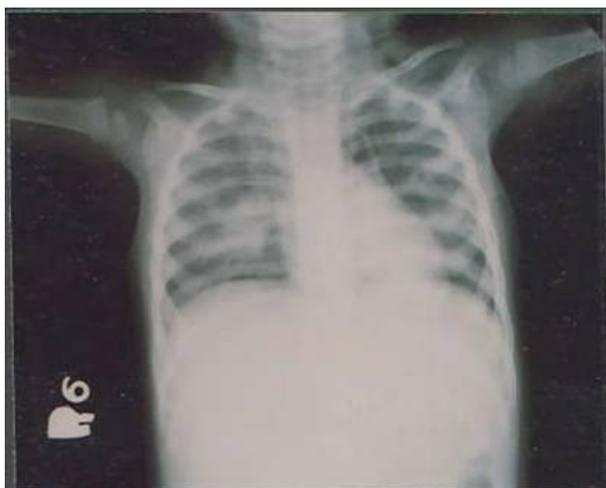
X-ray chest AP Supine, Arjun, 8 month male child showing consolidation right middle zone.
